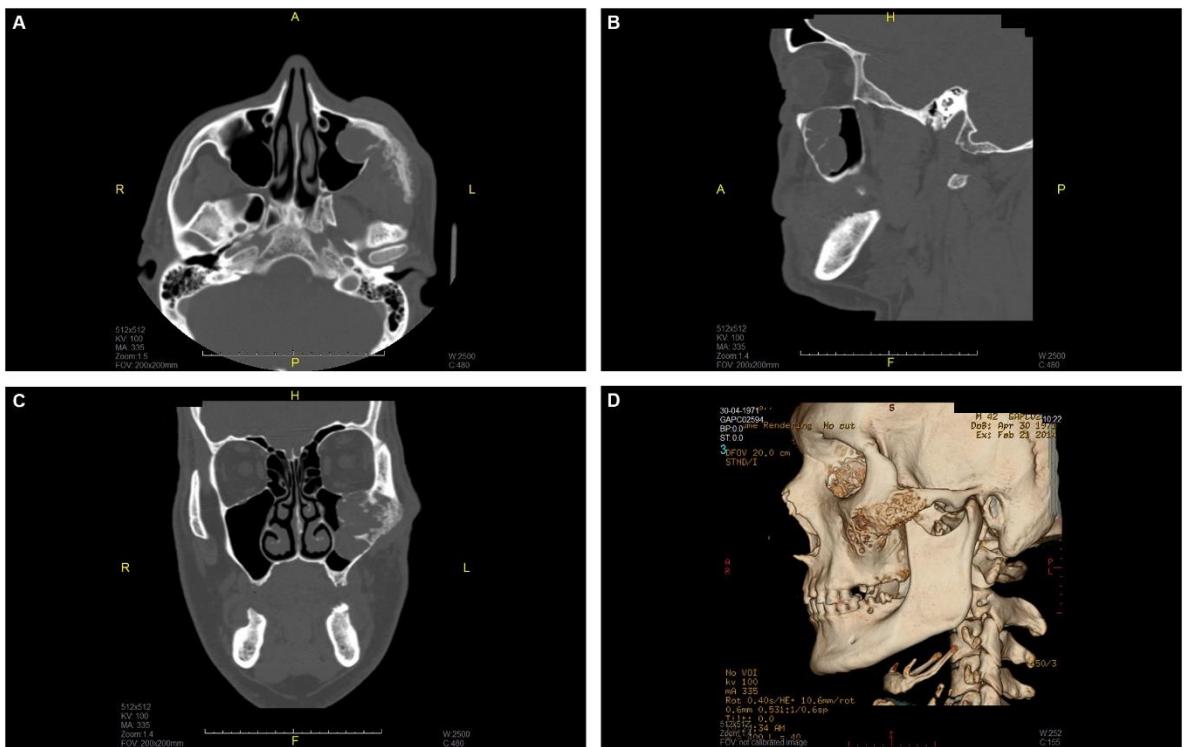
CT scans in coronal (A), sagittal (B) and axial (C) views and 3-dimensional reconstruction in a lateral view (D)
